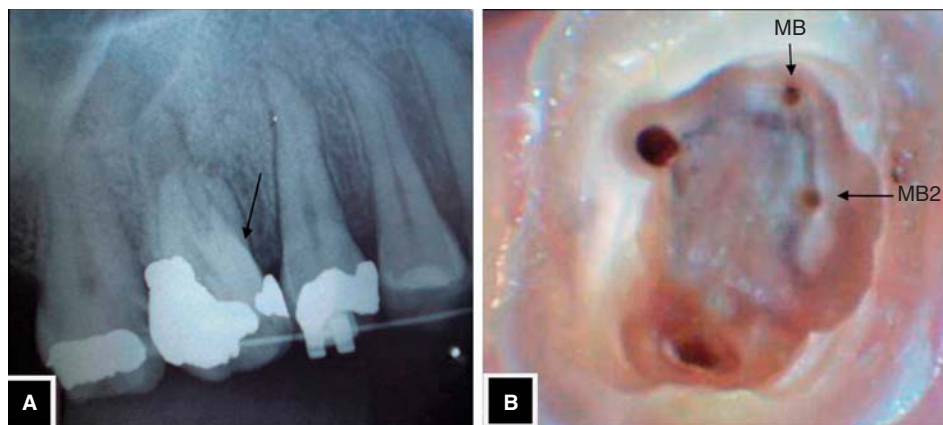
Maxillary first molar with 4 canals: (A) Initial periapical radiograph showing two canals in the MB root (arrow); (B) MB and MB2 canals in the MB root.
